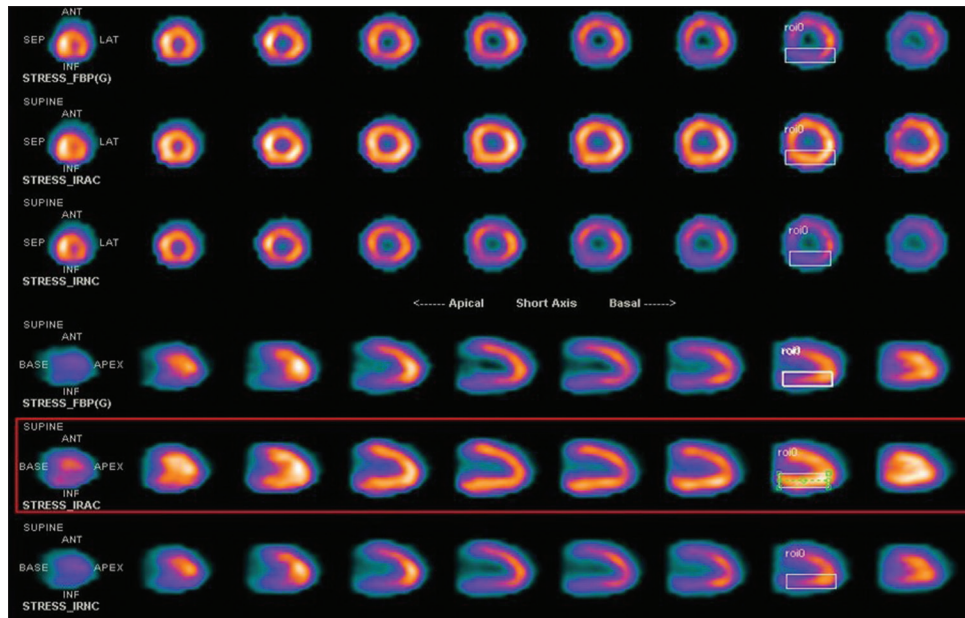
Vertical long axis (VLA) and short axis (SA) slices from myocardial perfusion images of a 66-year-old obese man without AC and with AC. Note the reduce in the inferior wall of the myocardium in the FBP and the IRNC images due to diaphragmatic attenuation, which was corrected on the attenuation compensated (IRAC) images. Also, no difference in the image quality was observed between FBP and IRNC images. Greater image homogeneity was demonstrated with IRAC. FBP, IRAC (CT-based AC), IRNC (CT-based nonAC)
